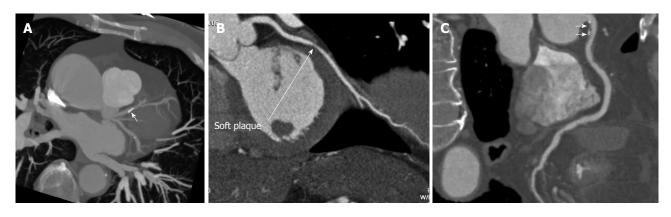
Characterization of coronary plaques on coronary computed tomography angiography. Coronal maximum intensity projection shows a calcified plaque (A, arrow) at the proximal segment of left coronary artery. A non-calcified plaque is present at the mid-segment of right coronary artery (B, arrow) on a curved planar reformation image. A mixed plaque is present at the proximal segment of right coronary artery (C, arrows) on a curved planar reformation image.
